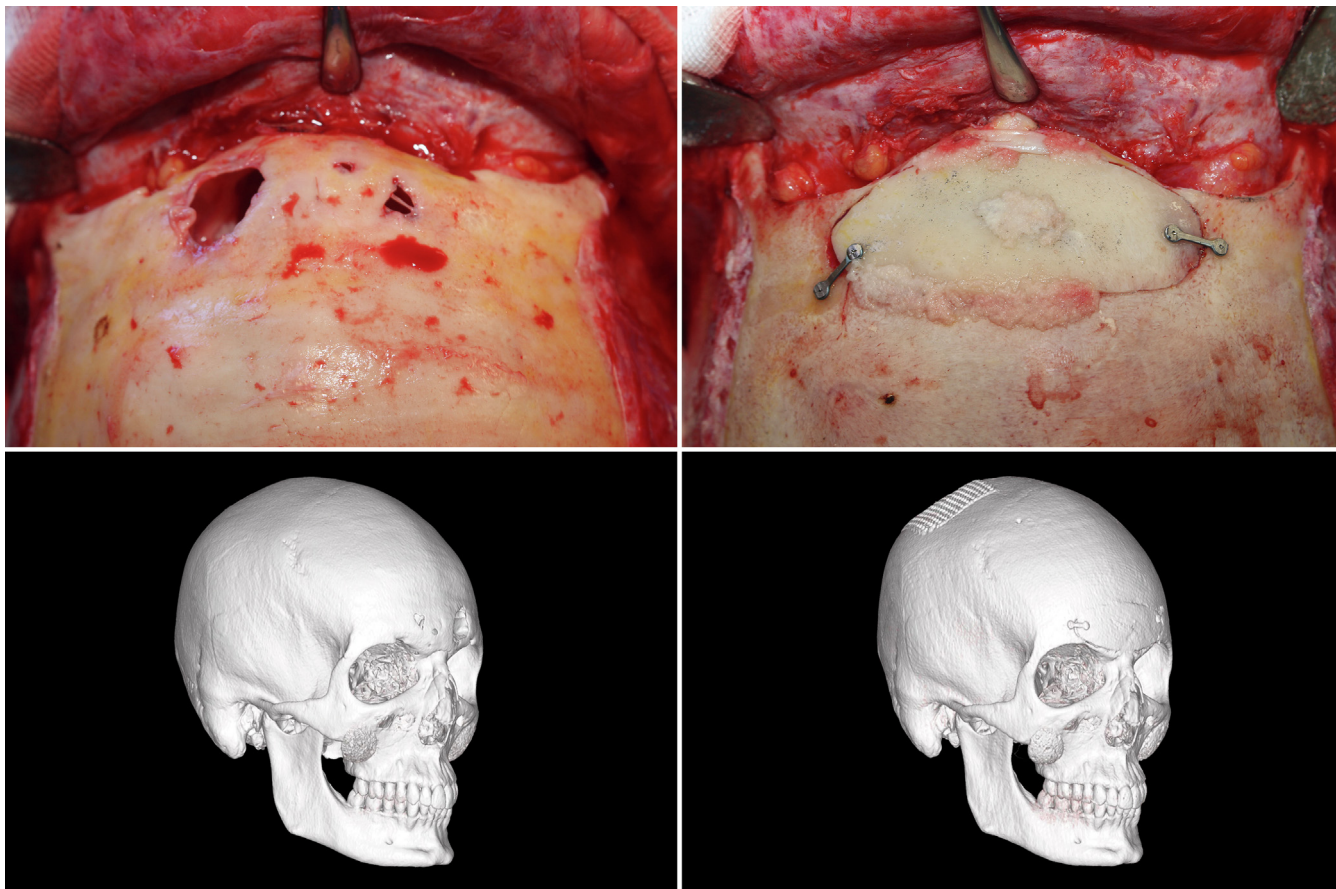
Secondary frontal sinus reconstruction. Case 2. Failed primary surgery performed elsewhere, with partial resorption of the anterior wall of the frontal sinus. (Top row) Intraoperative views before reconstruction (left) and after reconstruction with a parietal calvarial bone graft secured with titanium miniplates (right); residual defects were filled with autologous bone particulate and leukocyte- and platelet-rich fibrin. (Bottom row) Three-dimensional computed tomographic reconstructions demonstrating restoration of frontal bone surface continuity and sinus contour.
